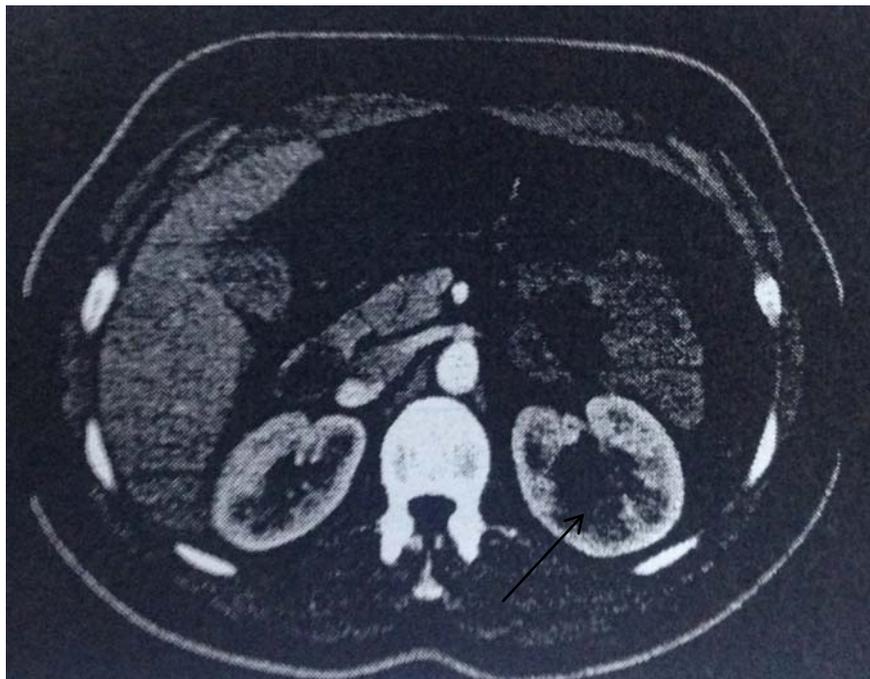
Computed tomography showing parynchymal cystic lesion with enhancing septations (arrow) at the upper pole of the left kidney 2.7*3.6*3.5 cm (Bosniak classification 3)
